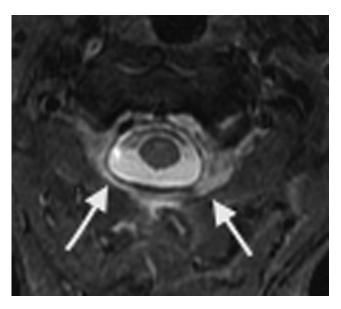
Axial short tau inversion recovery MR image of the cervical spine shows abnormal T2 signal in the paraspinous soft tissues (arrows).
